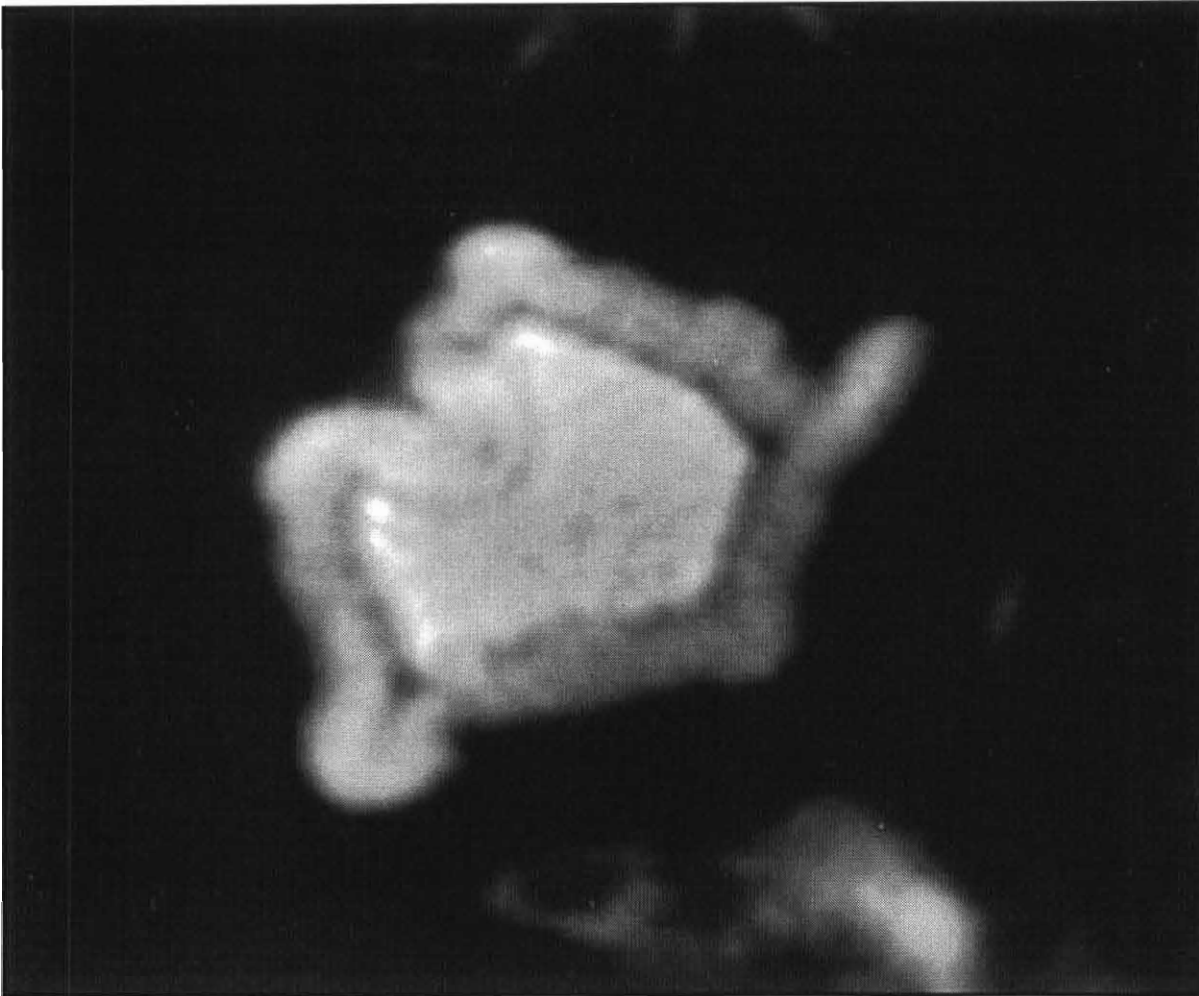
A T2-weighted magnetic resonance image revealed a high-intensity tortuous mass consistent with a deteriorated buckle.
